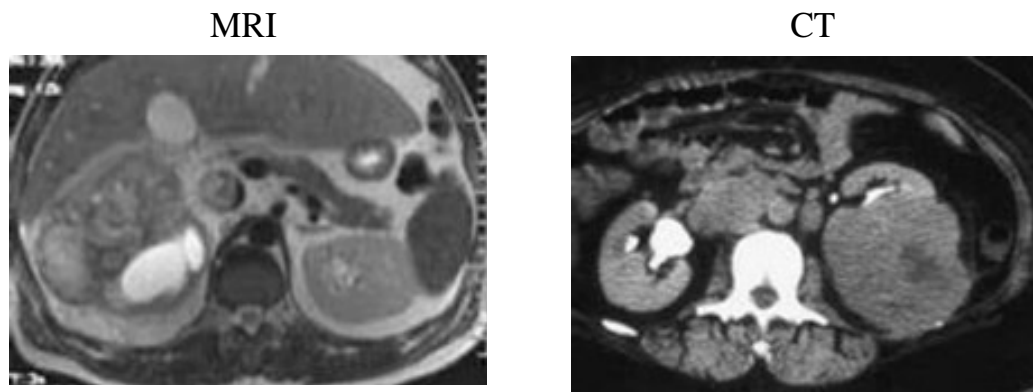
Sample MRI (left) and CT (right) images of patients with renal cell carcinoma.
